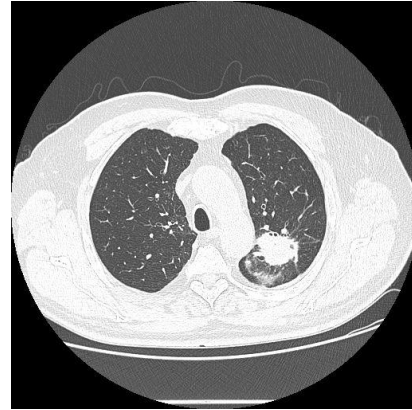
Computed tomography scan of lung (09/2023): stationary left upper lobe tumor, appearance of new nodular lesions in segment 3 of left lung and fine nodular lesions in segment 10 of right lung.
